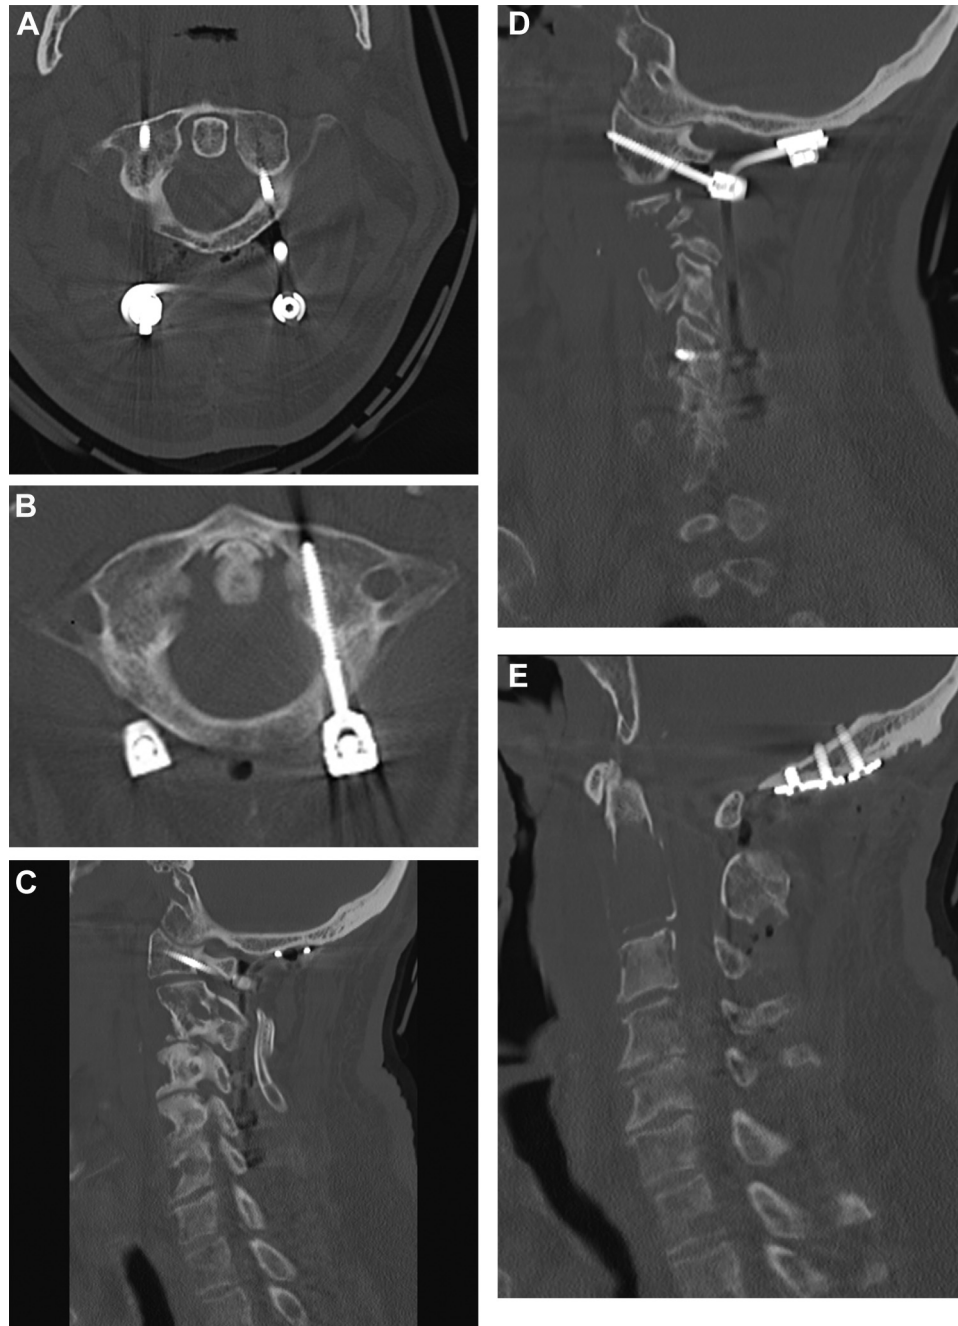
(A and B) Axials of postoperative computed tomography (CT) of the C1 ring demonstrating good entry points and trajectories of the C1 screws. (C) Left parasagittal postoperative CT. (D) Right parasagittal postoperative CT. (E) Midsagittal postoperative CT demonstrating nice realignment of the pathologic fracture of C2 and correction of kyphosis.
